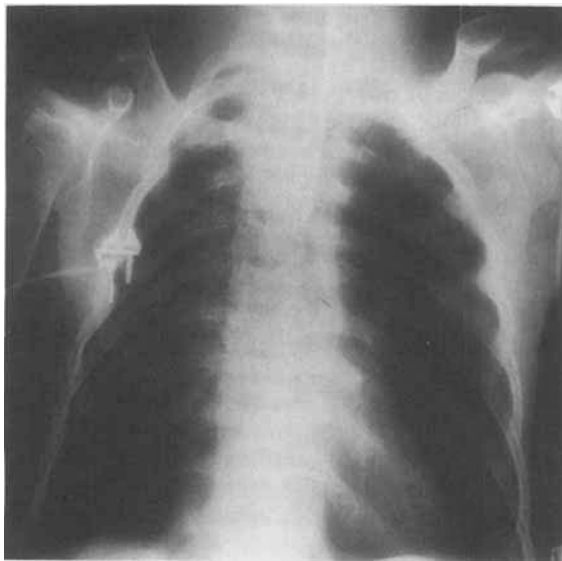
Propositus (patient 1), age 15 years. Radiograph demonstrates shortening and marked distal deformity of clavicle.
